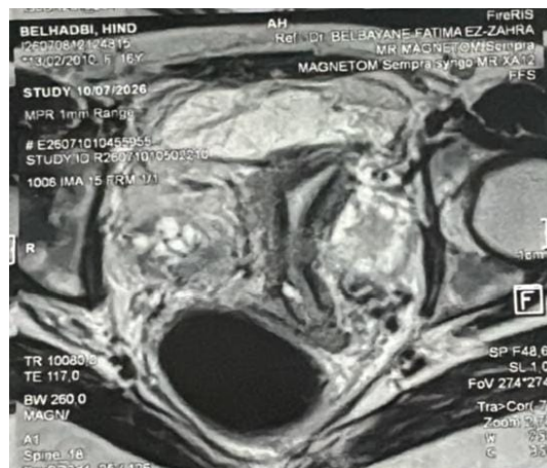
Axial pelvic magnetic resonance imaging demonstrating bilateral complex latero-uterine/adnexal lesions consistent with tubo-ovarian abscesses.
